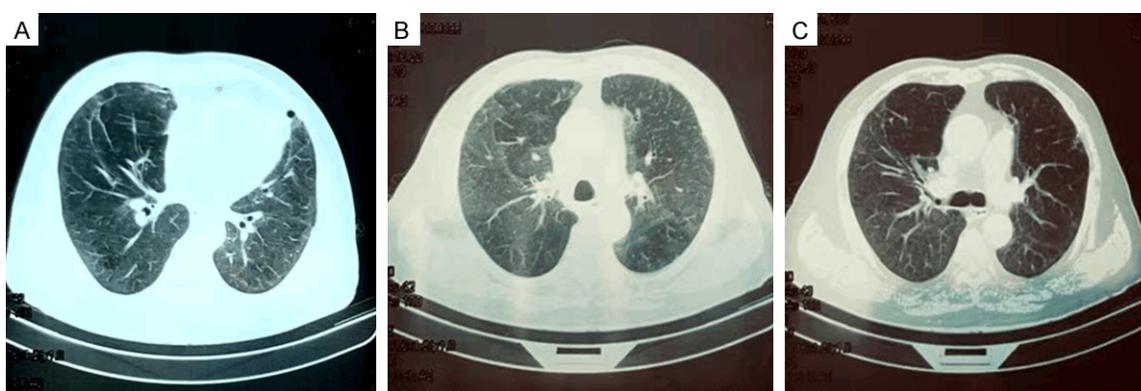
Chest CT scan from the same case as Figure 2, showing the reexamination after four months of illness. A. The first level. B. The second level. C. The third level.
